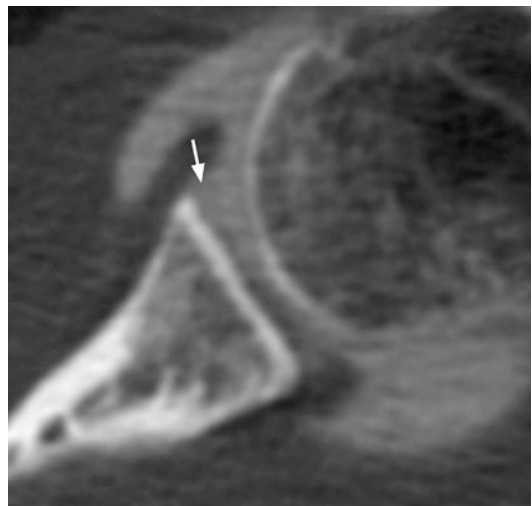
Axial CT arthrogram in patient following anterior dislocation showing absence of the anterior labrum (arrow) which had retracted inferiorly
